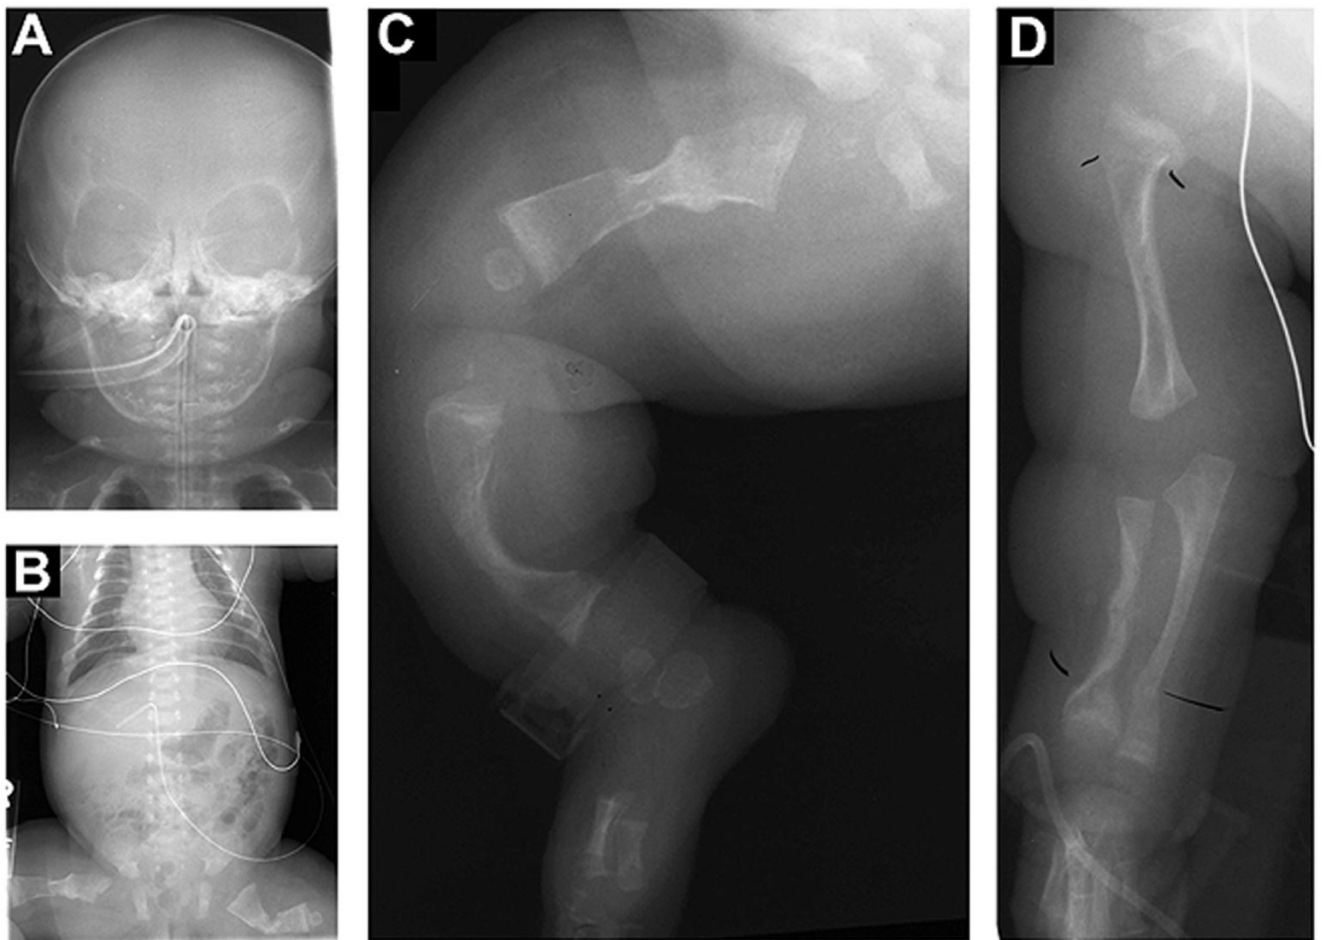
Early radiographs of Proband 7 with *LEPRE1* nonsense mutation. *A, B, C, D*, radiographs of Proband 7 at birth, consistent with severe OI, found to have a homozygous nonsense mutation in *LEPRE1*, c.392C>A, p.Ser131X.
